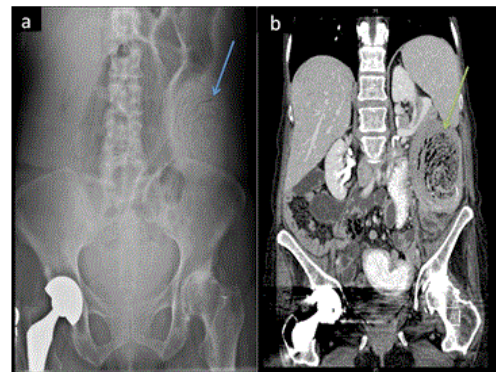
a) Abdominal X-ray: a large rounded area of mottled gas and soft tissue (blue arrow). b) Contrast-enhanced CT of the abdomen, coronal view: a large 14 cm mixed air and soft tissue density mass in the colon splenic flexure (green arrow).
